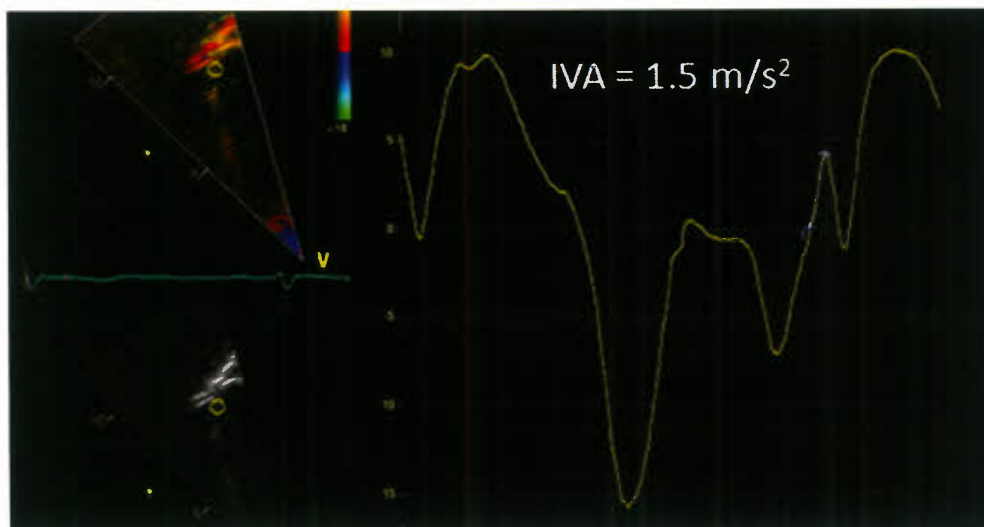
Isovolumetric acceleration measured in the RV lateral annulus from an apical four-chamber view. The measurement is performed using color tissue Doppler traced at high frame rates (>180 frames/s). The acceleration of the isovolumetric spike is measured from the baseline to the peak.
